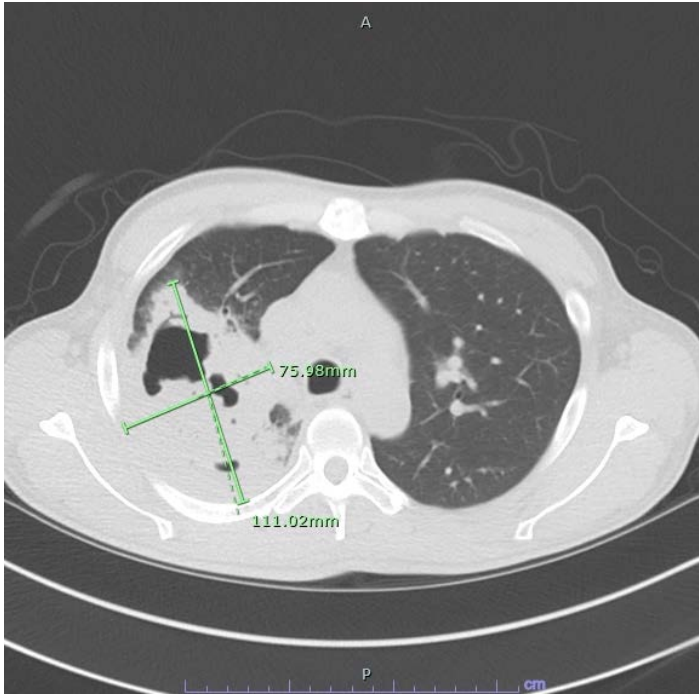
CT chest showed an interval enlargement of 7.6 x 11.1cm complex multiloculated cavitary lesion in the right upper lobe.
